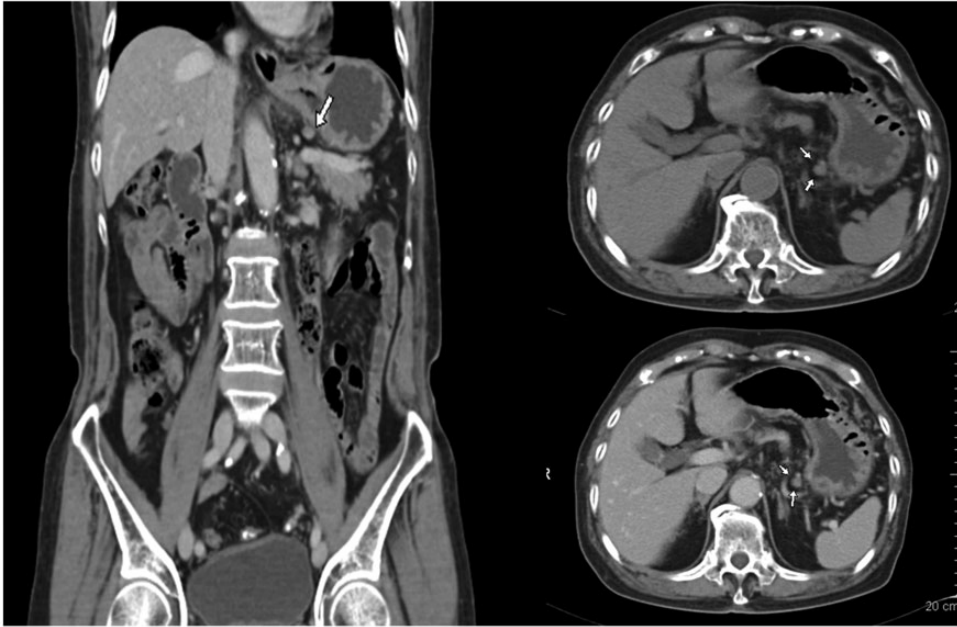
Computed tomography (CT) manifestations of metastatic lymph nodes. This figure shows the images of an 83-year-old man with ulcerative-type moderately differentiated canalicular adenocarcinoma in the gastric antrum. The arrow indicates the No. 1 right cardia lymph nodes. The short diameter of the lymph nodes is 6.1 mm, the flat CT value is 40.6 HU (≥ 25 HU), and the mild/moderate enhancement CT value is 69.8 HU (≤ 75 HU). The presence of metastasis was confirmed by pathologic examination.
